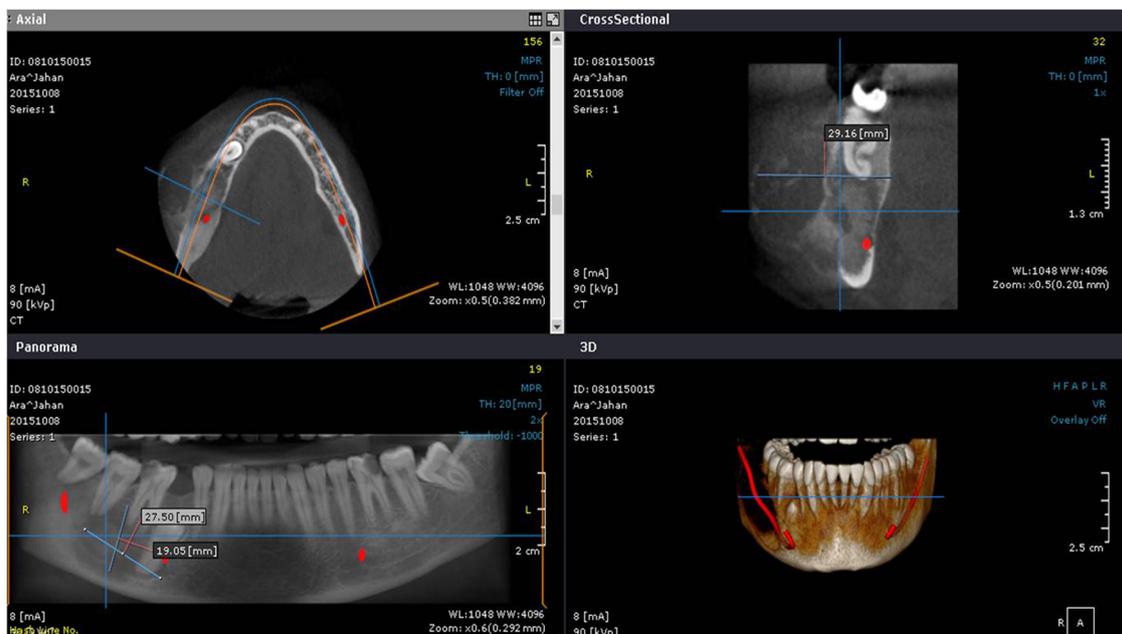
Cone beam computed tomography showing the mixed radiopaque-radiolucent lesion in the axial, cross-sectional, panoramic and 3D views.
